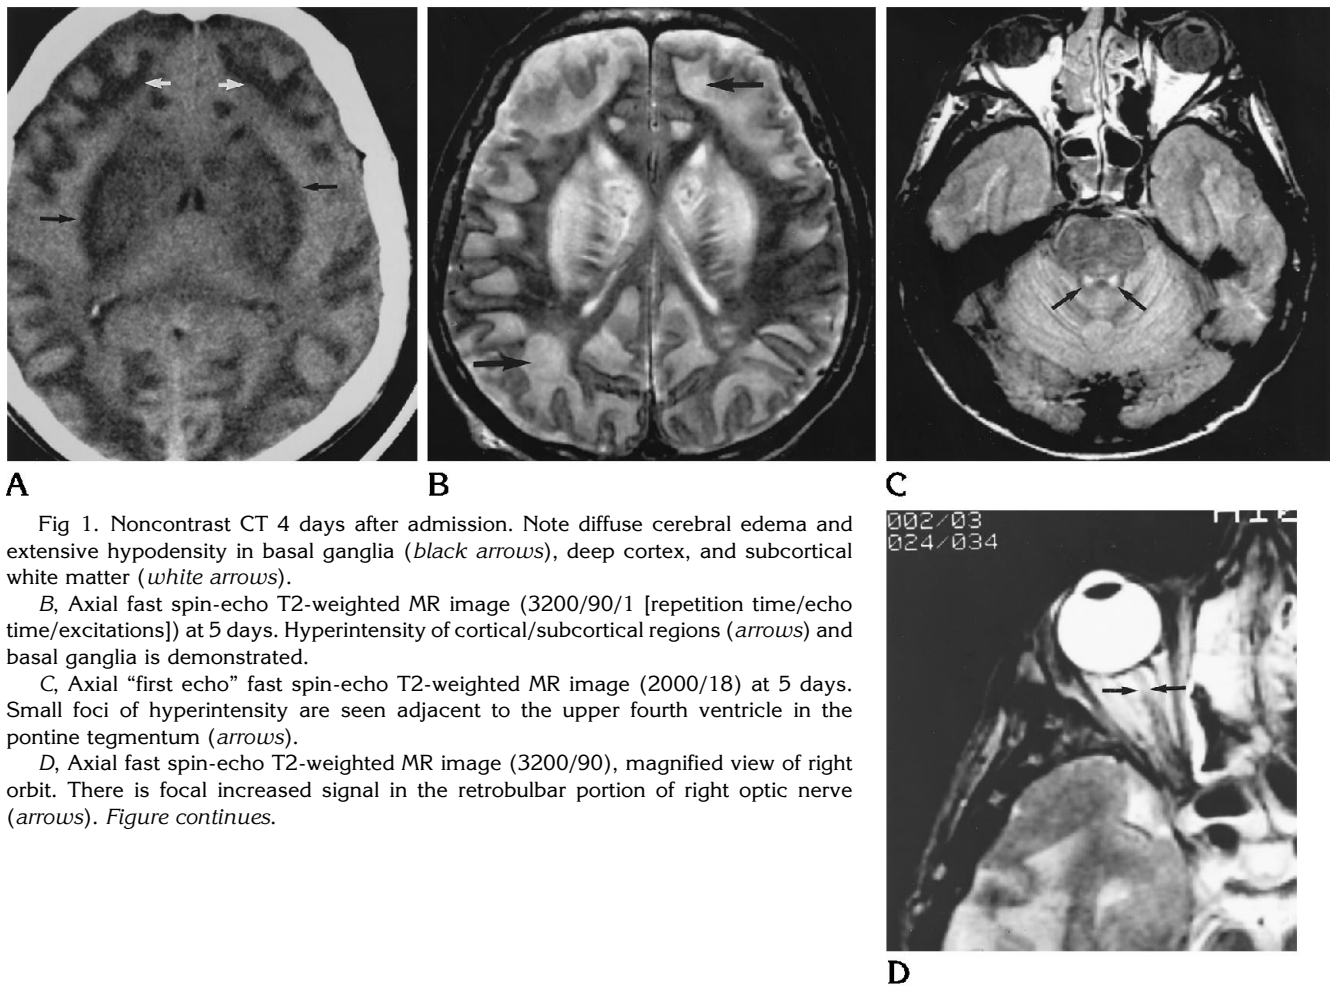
Noncontrast CT 4 days after admission. Note diffuse cerebral edema and extensive hypodensity in basal ganglia (*black arrows*), deep cortex, and subcortical white matter (*white arrows*).
